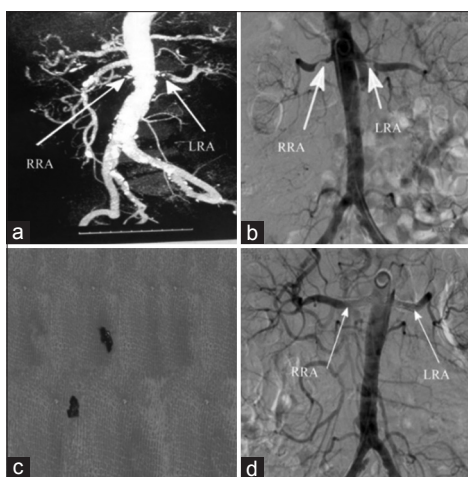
Imaging manifestations of preoperative, intraoperative and postoperative of intervention treatment on renal artery embolization (a) CTA of the renal arteries showed filling defects (as the arrows pointing) in both proximal renal arteries (suspected emboli). (b) Renal artery angiography showed bilateral renal artery root filling defect (as the arrows pointing), suggestive of emboli; (c) the thrombi were removed during surgery. (d) Normal blood flow in both renal arteries was restored after surgery (as the arrows pointing). RRA: Right renal artery; LRA: Left renal artery; CTA: Computed tomography angiography.
